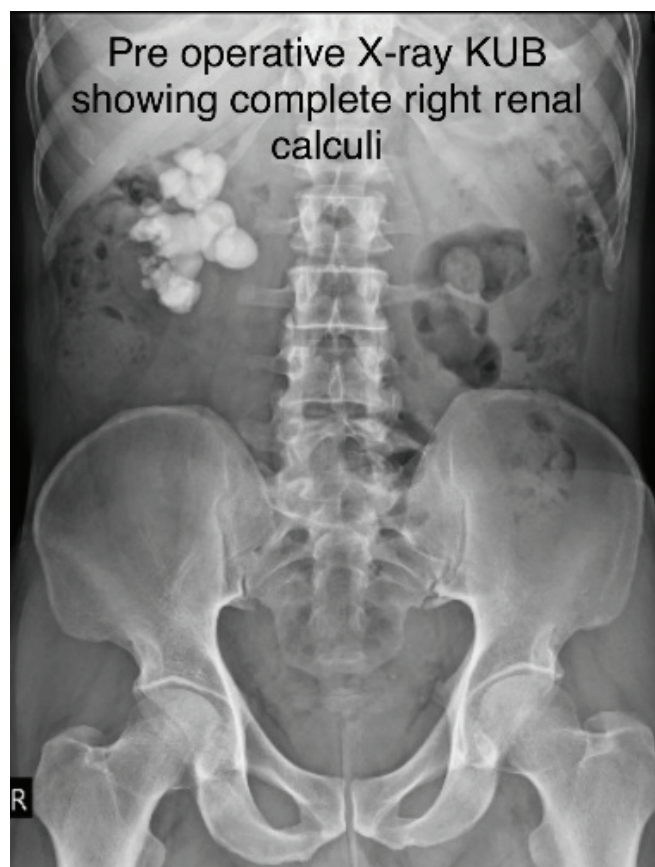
Pre-operative X-ray KUB showing complete right renal calculi
